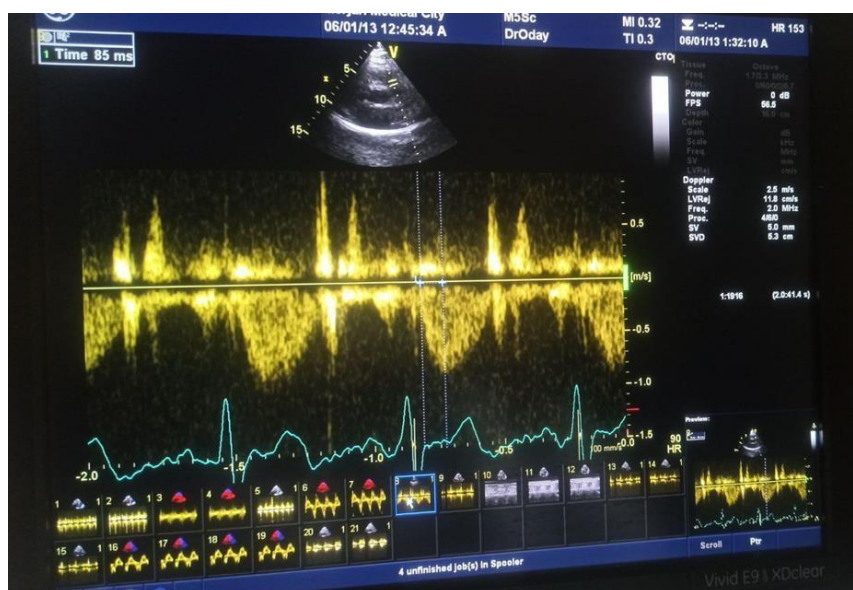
PW, Doppler measurement of pulmonary acceleration time (PAAT)
